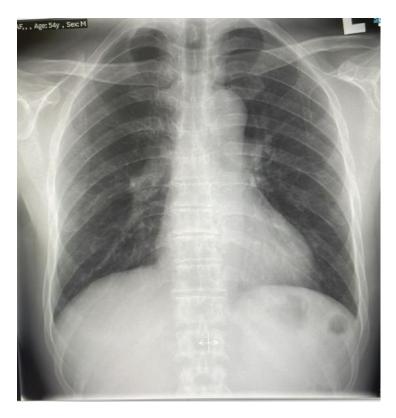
Chest Radiography showing no significant findings.
